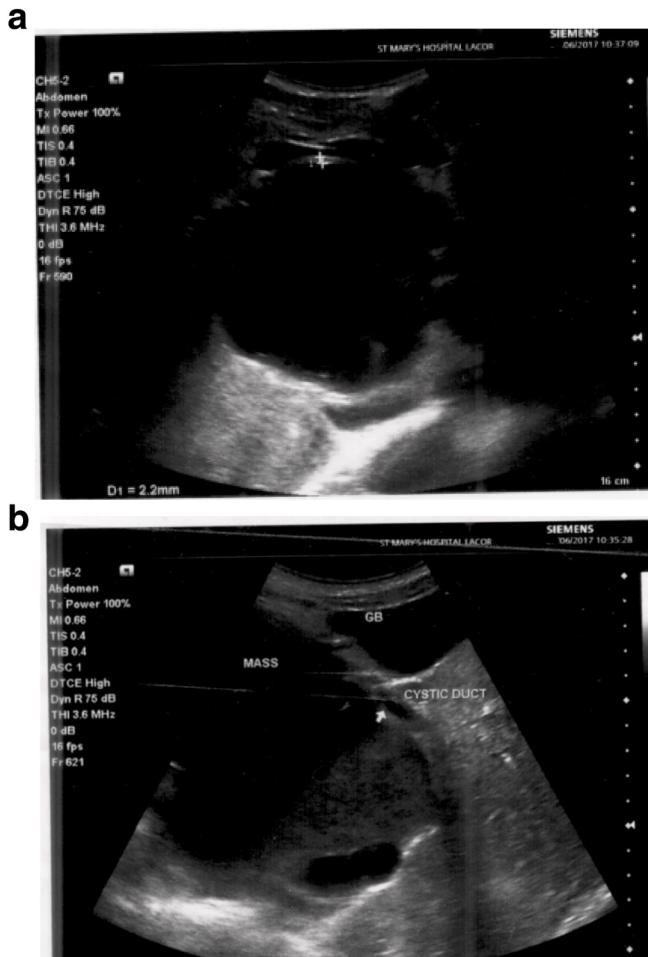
Follow-up ultrasound findings. (a) Follow up sonogram obtained after percutaneous transhepatic cholangiography (images not retrieved) show a large sonolucent sub hepatic left liver lobe mass 12×11 cm, with a wall thickness of 0.22 cm. (b) Follow-up sonogram obtained after percutaneous transhepatic cholangiography revealed biloma mass adjacent to the gall bladder with internal debris.
